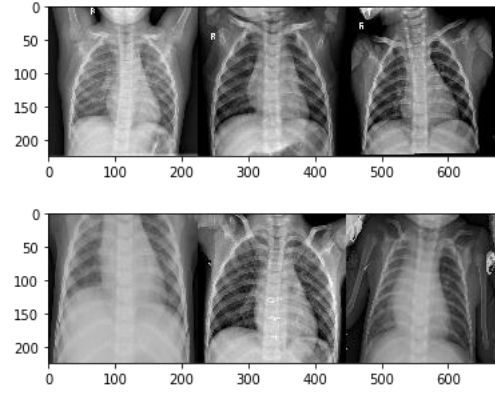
The first row of images are X-Ray images of patients whose lungs are in normal condition (not pneumonia affected). The second row of images are the X-Ray images of lungs of pneumonia patients
